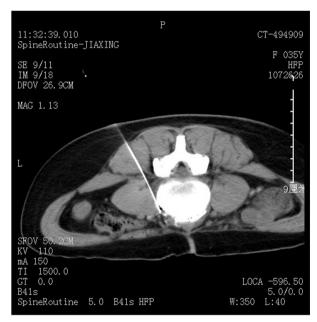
A needle puncturing the target point under computed tomographic guidance (left side: puncture toward the anterolateral margin of the L5 vertebral body and the anterior margin of the psoas major muscle through paravertebral puncture; right side: puncture below the iliac bifurcation of the abdominal aorta through intervertebral disc puncture).
